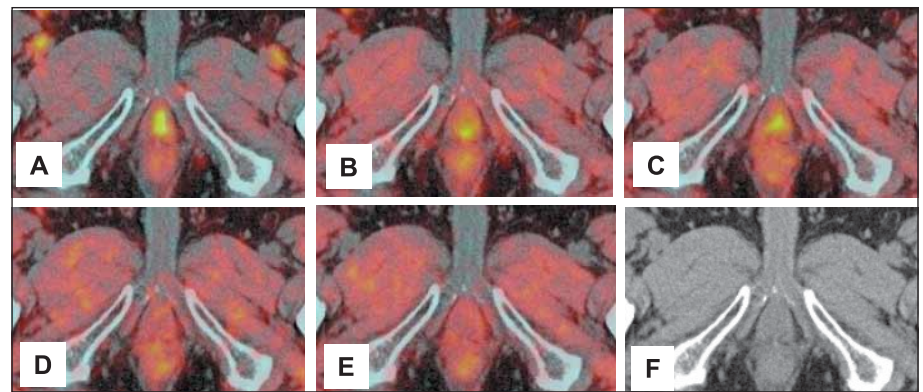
Three-phase PET/CT (frames are identical as in Figure 1) showing the late disappearance of vascular activity at bulbar level. Dynamic scanning (A-C) shows that vascular bulbar activity persists until frame C (6–9 min p. i.) and disappears on frames D and E.
